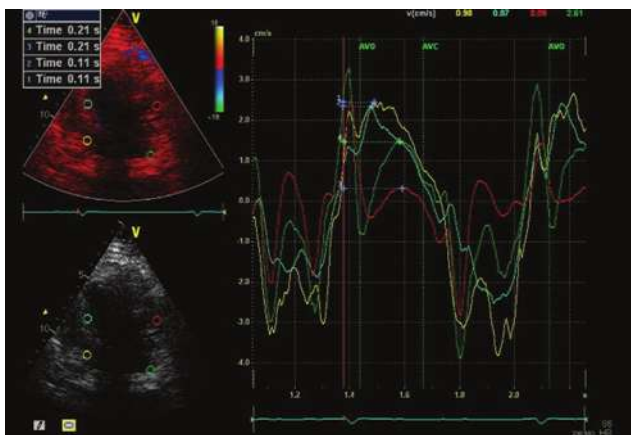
Offline analysis of tissue doppler imaging on segments assessed for dyssynchrony
